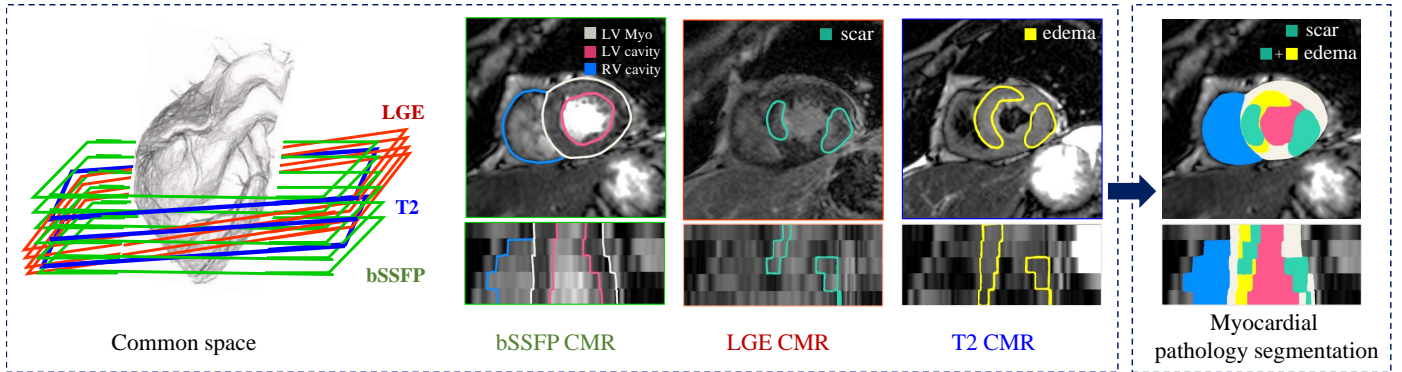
Visualization of myocardial pathology segmentation combining three-sequence cardiac magnetic resonance images acquired from the same patient (figure designed referring to Zhuang (2019)).
